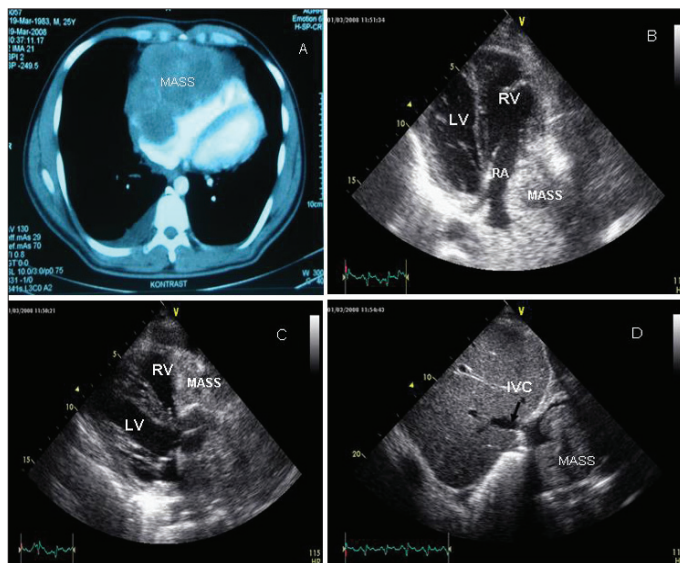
A) Thorax computed tomography view of a lobulated mass located at anterior mediastinum. B) A two-dimensional echocardiographic apical four-chamber window view of a mass. C) The view of the same mass from parasternal long-axis and subcostal (D) views
